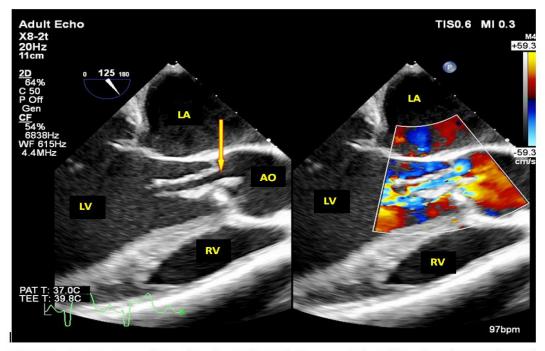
Transoesophageal Echocardiography Long Axis View Showing Perforated Aortic Valve Leaflet (arrow) with Severe Aortic Regurgitation
